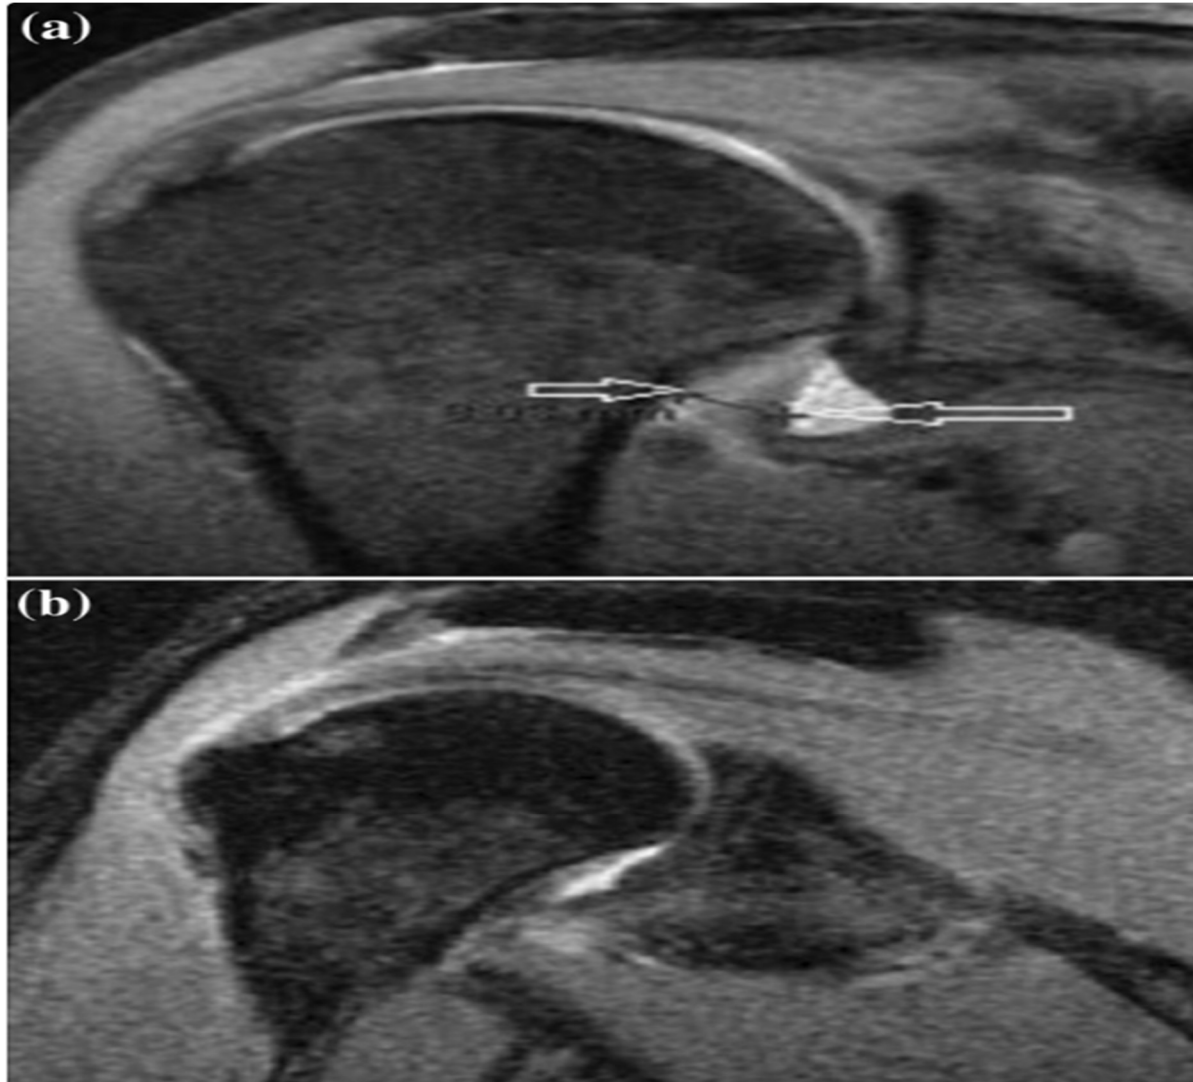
MRI Imaging of the Shoulder Joint in Frozen Shoulder (a Fat suppressed Proton Density Fast Spin Echo oblique coronal image shows thickened (7.4 mm) joint capsule and synovium (opposed arrows) in a subject with adhesive capsulitis, b control subject for comparison.)
